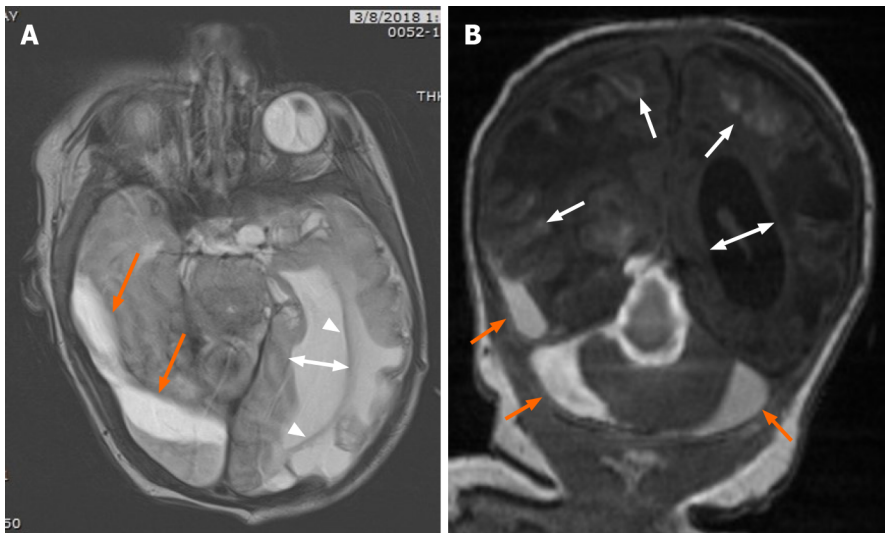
Follow-up magnetic resonance imaging on 20th day of life. A: Follow-up magnetic resonance imaging on 20th day of life revealed evolving blood products (orange arrows) in the subdural space on axial T2, with interval left greater than right cystic encephalomalacia in the parietal and occipital lobes and left greater than right ex-vacuo dilatation of the lateral ventricles (two direction arrow); B: Coronal T1 demonstrates degrading blood product in the right temporal lobe subdural space, and central and peripheral infratentorial subdural spaces (orange arrows) with cortical laminar necrosis (arrows) and increasing obstructive hydrocephalus (two-direction arrow).
